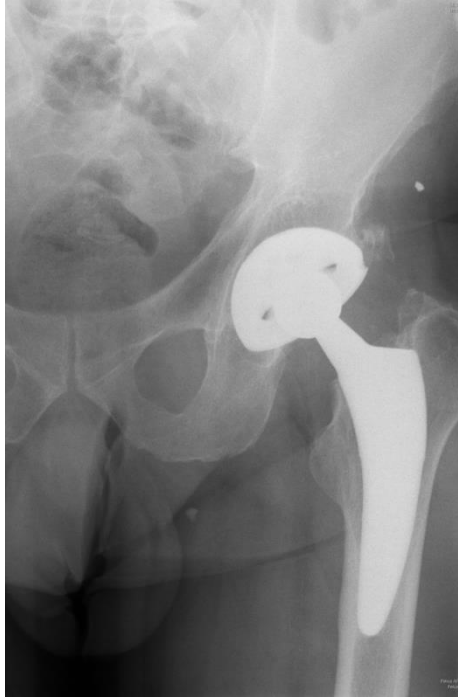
Follow-up radiograph of the pelvis 3 years after left hip arthroplasty. We can see the cortical hypertrophy in Gruen zone 5
